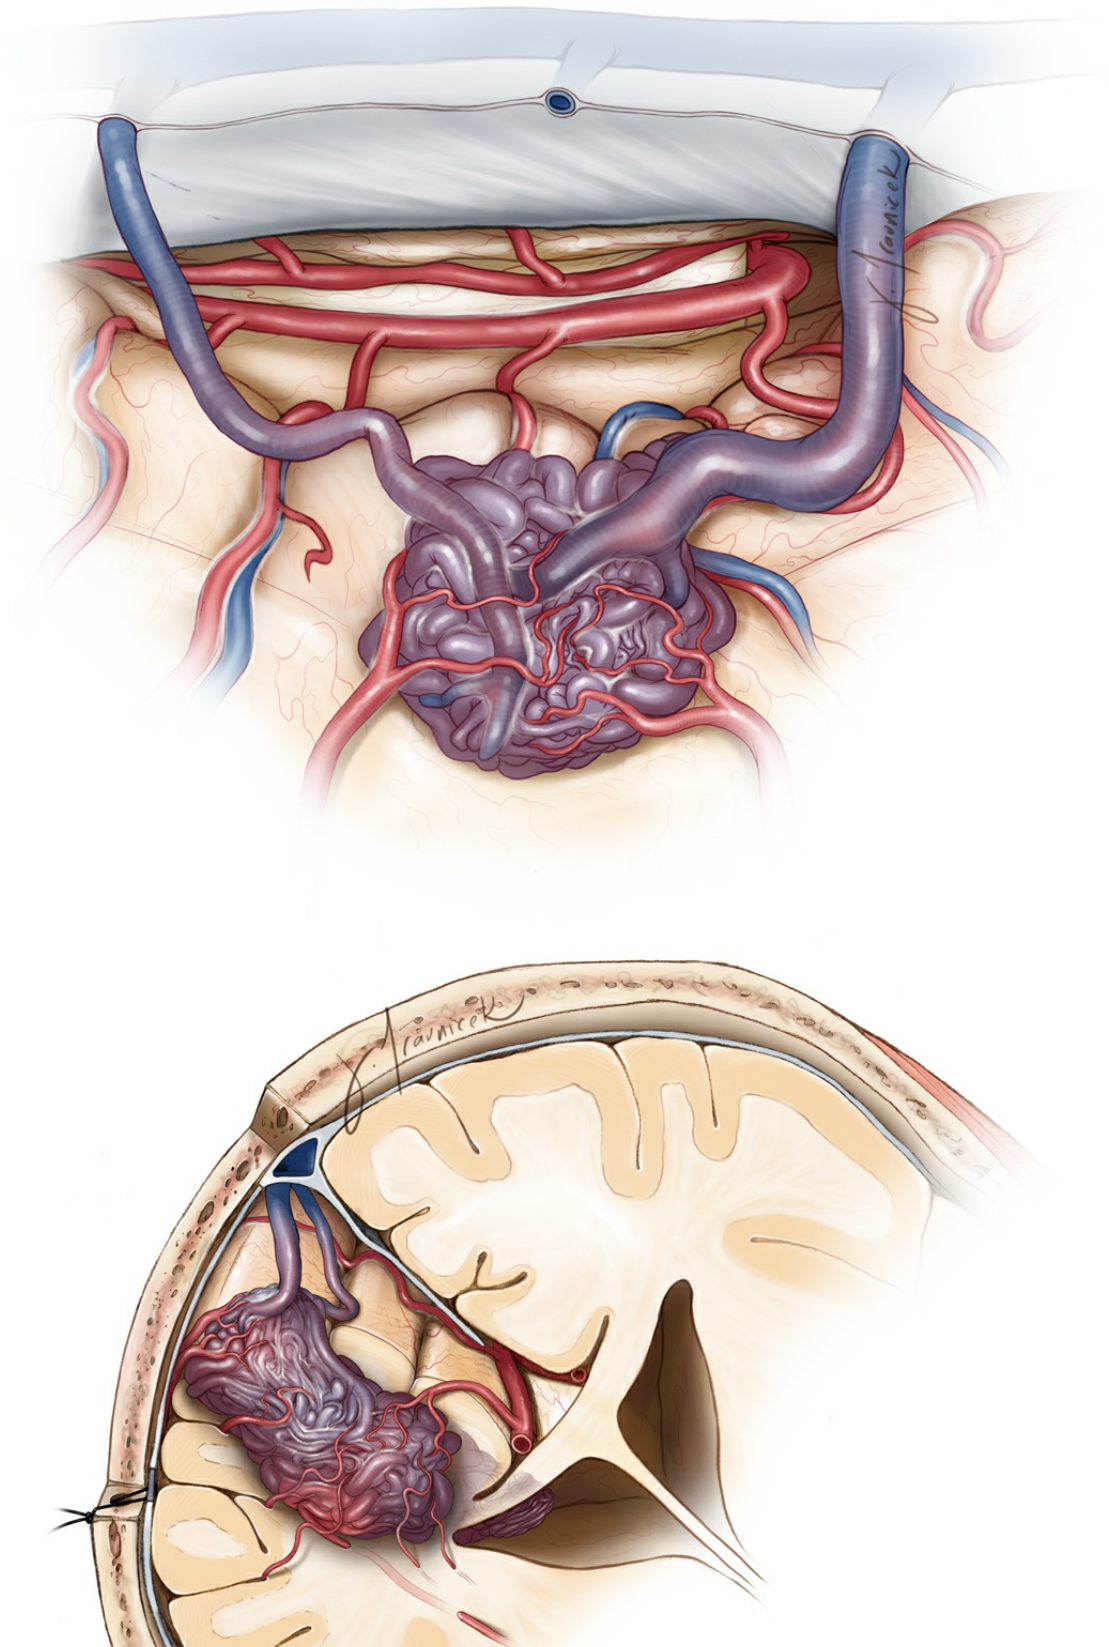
The AVM in Figure 10 is first disconnected along its interhemispheric margin from the ACA feeders (upper image). Next, the MCA supply is disrupted on the lateral convexity using pial incisions guided by intraoperative CTA navigation (lower image). The head is in the anatomically neutral position.
